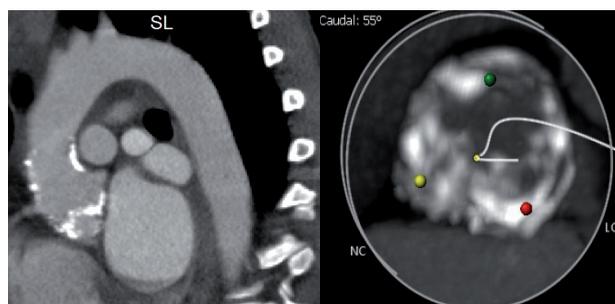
Left, CT angiography showing severe homograft calcification, including annulus and valve. Right, cross sectional images of aortic valve calcifications.
